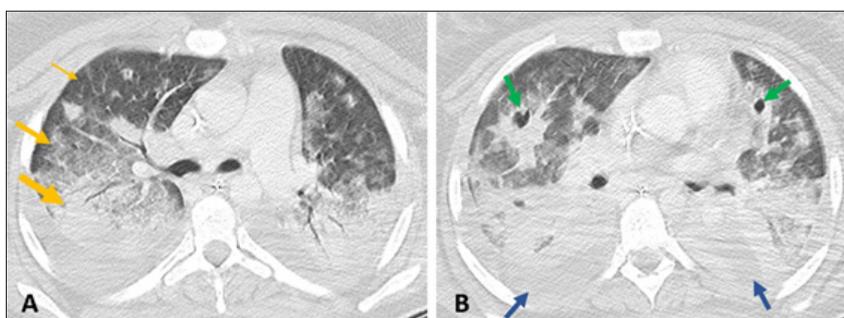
Contrast-enhanced chest CT scan, lung window (axial plane at two different levels – A and B) shows increase in size and cavitation of the previously identified lung nodules (green arrows - B), confirming the hypothesis of pulmonary septic emboli. In contrast to the previous CT scan, bilateral pleural effusion is now seen (blue arrows) and a radiological pattern of acute respiratory distress syndrome (ARDS), with an anteroposterior density gradient, resulting from dense consolidation in the most dependant regions (thick yellow arrow), followed by ground-glass attenuation (medium yellow arrow) and normal lung in the non-dependant regions (thin yellow arrow), in line with the progressive respiratory insufficiency.
